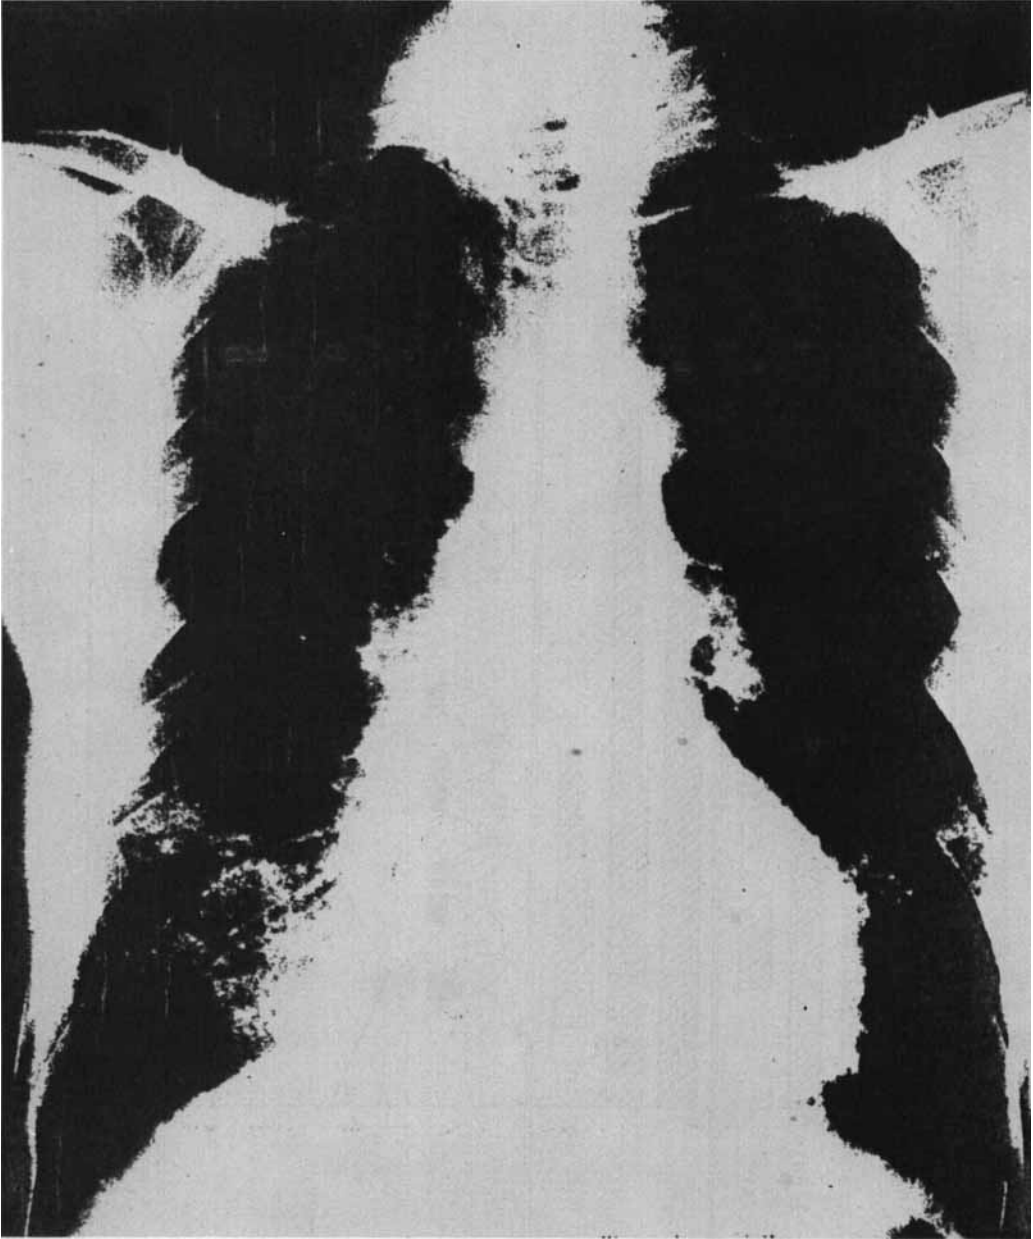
Chest X-ray picture of a PSS patient suffering from progressive lung fibrosis and dyspnea.
